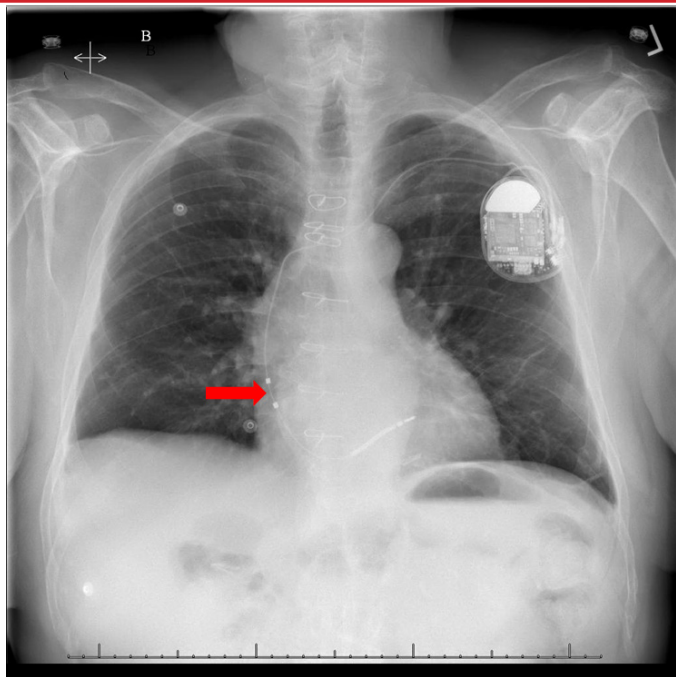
A chest X-ray image showing placement of the Biotronik Linx Smart DX active fixation lead in the septum
